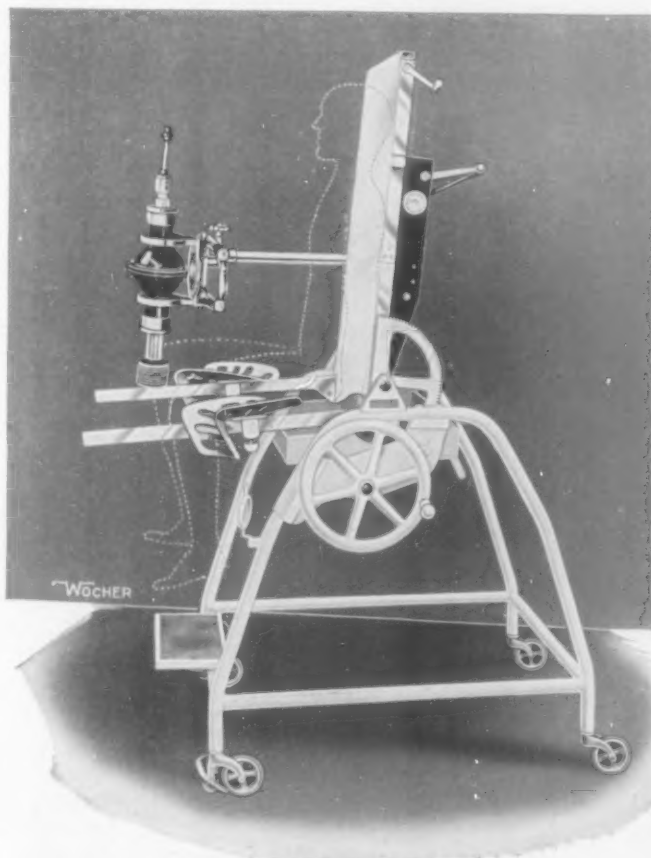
Young's combined cystoscopic and X-ray table with patient in vertical position sitting upon the movable side bars. This position is used for vertical pyelograms which show the extreme movement of the kidneys.
